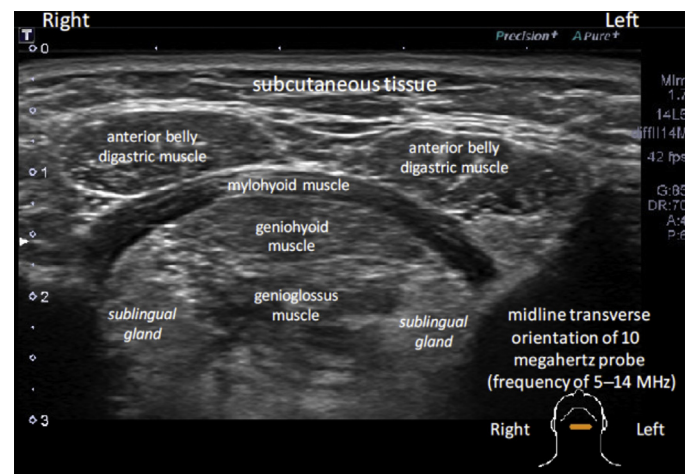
Normal submental evaluation of midline upper anterior neck ultrasound unit with midline transverse orientation using 10 MHz (frequency range, 5–14 MHz) probe.
